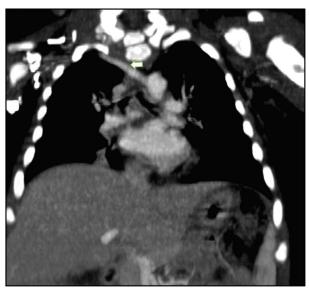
Axial image of a chest CT showing the ARSA passing posterior to the trachea and esophagus (arrow)
